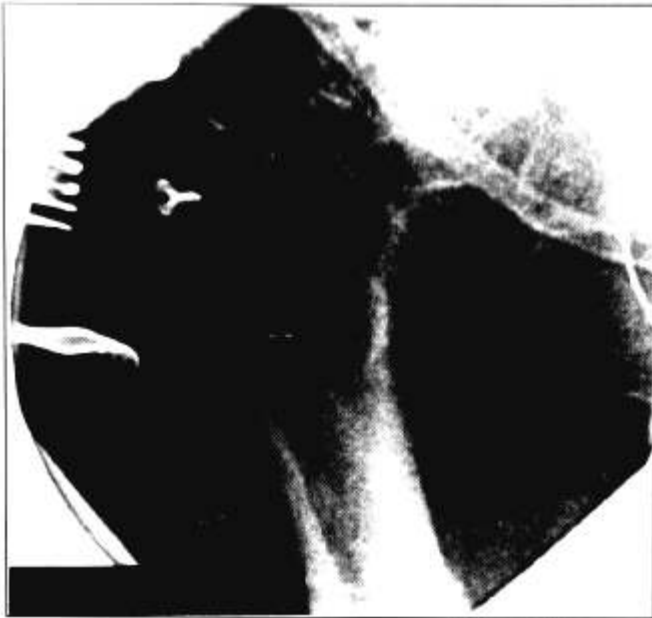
This fluoroscopic anterior/posterior x-ray view shows the locator pins in the greater trochanter.
